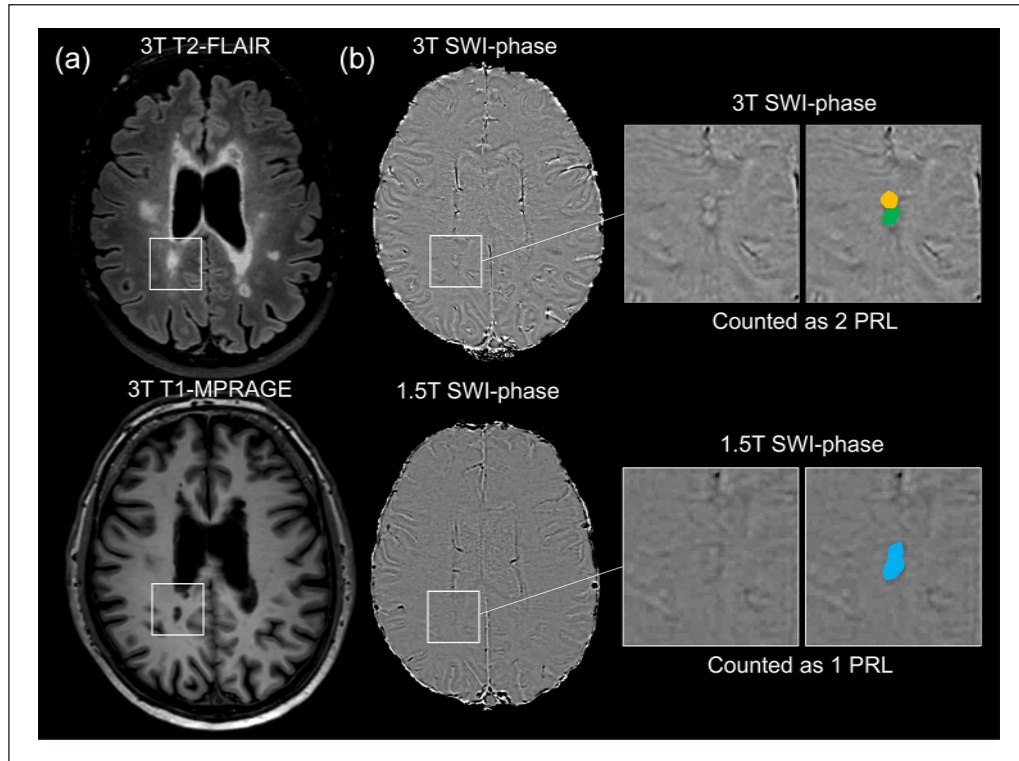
Discordant PRL count at 1.5T versus 3T MRI due to confluent lesions. (a) Axial 3D FLAIR and 3D T1 MPRAGE images from subject #13 (Table 1) show a lesion in the periventricular white matter of the right parietal lobe. (b) On 3T axial SWI-phase images, the paramagnetic rim allows for the identification of two distinct PRLs. In contrast, on 1.5T axial SWI-phase images, the interface between the two lesions appears indistinct, leading to the classification of the lesions as a single PRL. Magnified images are shown in the insets along with the corresponding lesion masks.
